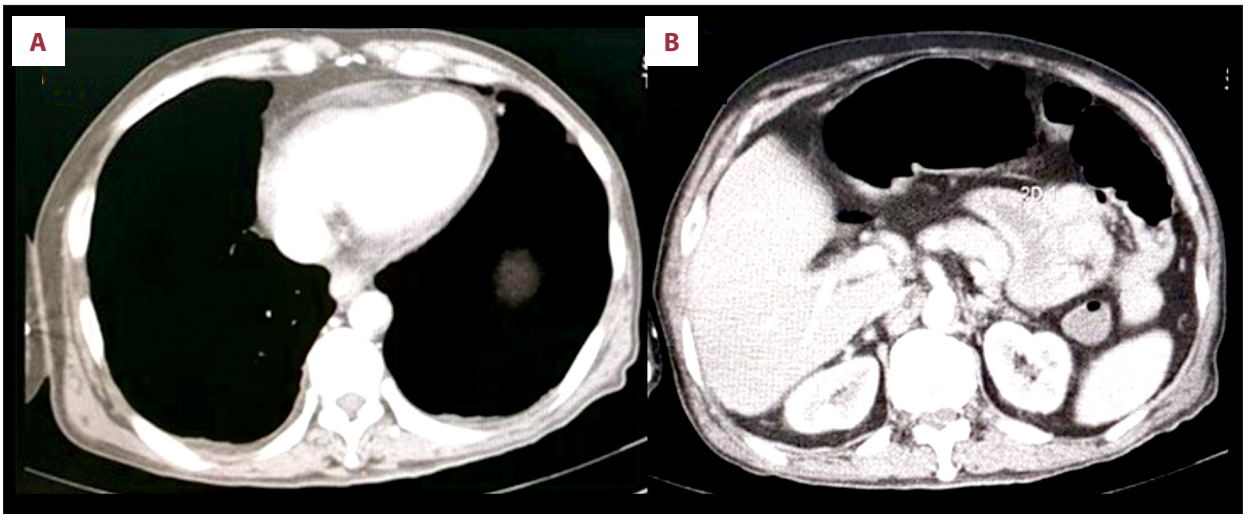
(A) CT scan contrast showed enhance pericardium, supporting pericarditis, (B) Mucosal thickening of enteritis.
